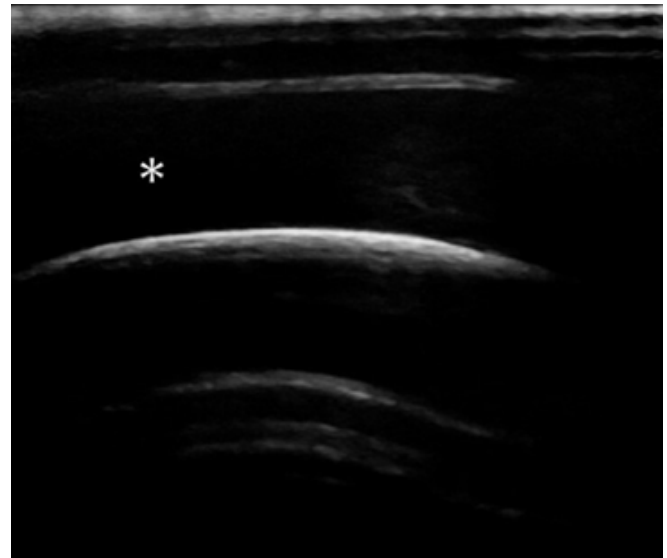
Ultrasonography of the subgaleal hematoma. The examination revealed a hypoechoic lesion (*).
